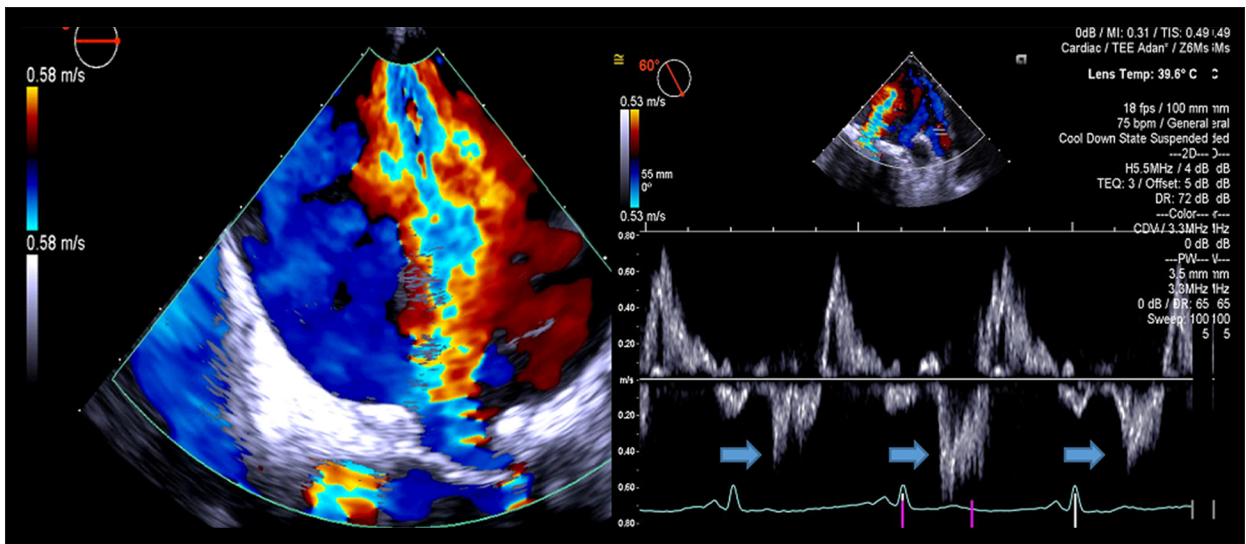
Preoperative transesophageal echocardiogram (TEE) showing severe mitral regurgitation with color Doppler and systolic flow reversal of the pulmonary vein in a 43-year-old man with a history of systemic lupus erythematosus (SLE) who presented with endocarditis, which was later diagnosed to be an infection with *Coxiella burnetii*. The TEE was performed in 2018.
